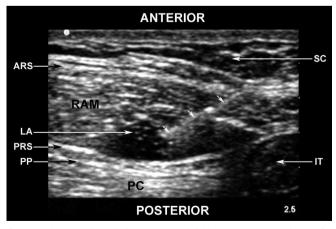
Ultrasound-guided rectus sheath block. ARS, anterior layer of rectus sheath; IT, intestine; LA, local anaesthetic; PRS, posterior layer of rectus sheath; PC, peritoneal cavity; PP, parietal peritoneum; RAM, rectus abdominis muscle; SC, subcutaneous tissue. The unlabelled arrows indicate the block needle.
